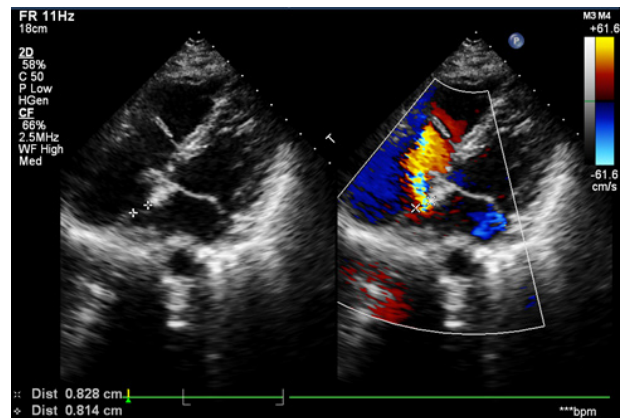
Transthoracic echocardiography shows a 0.8-cm defect between the right atrium (RA) and left atrium (LA), representing ASD. Color duplex ultrasound shows a left-to-right shunt.
